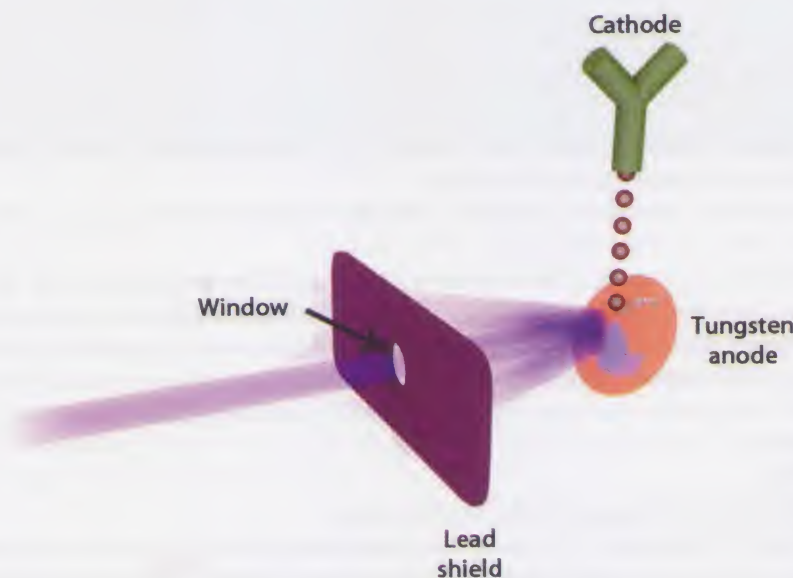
Production of x-rays
